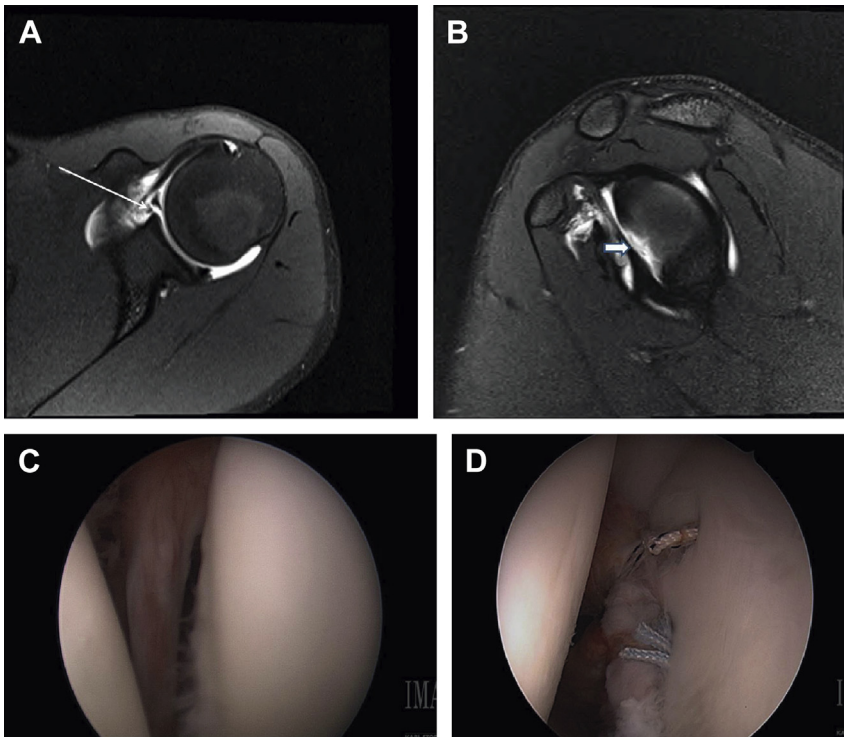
(A) MRI of the left shoulder in a 13-year-old boy after dislocation from a bicycle crash. Arrow shows labrum separation from glenoid on axial view. (B) Full arrow shows labral detachment from glenoid on coronal view. (C) Arthroscopic appearance of torn labrum. (D) Suture anchors placed in anterior labrum.
